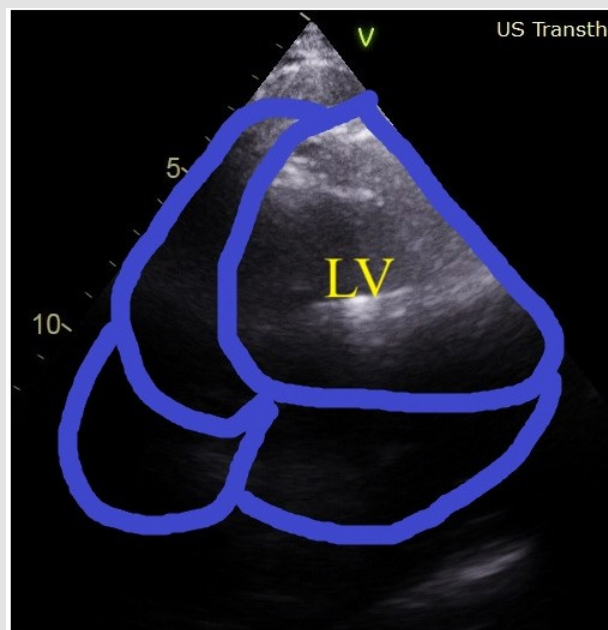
Massive dilation of left ventricle seen in echocardiography. Moderate dilation of left atrium.
